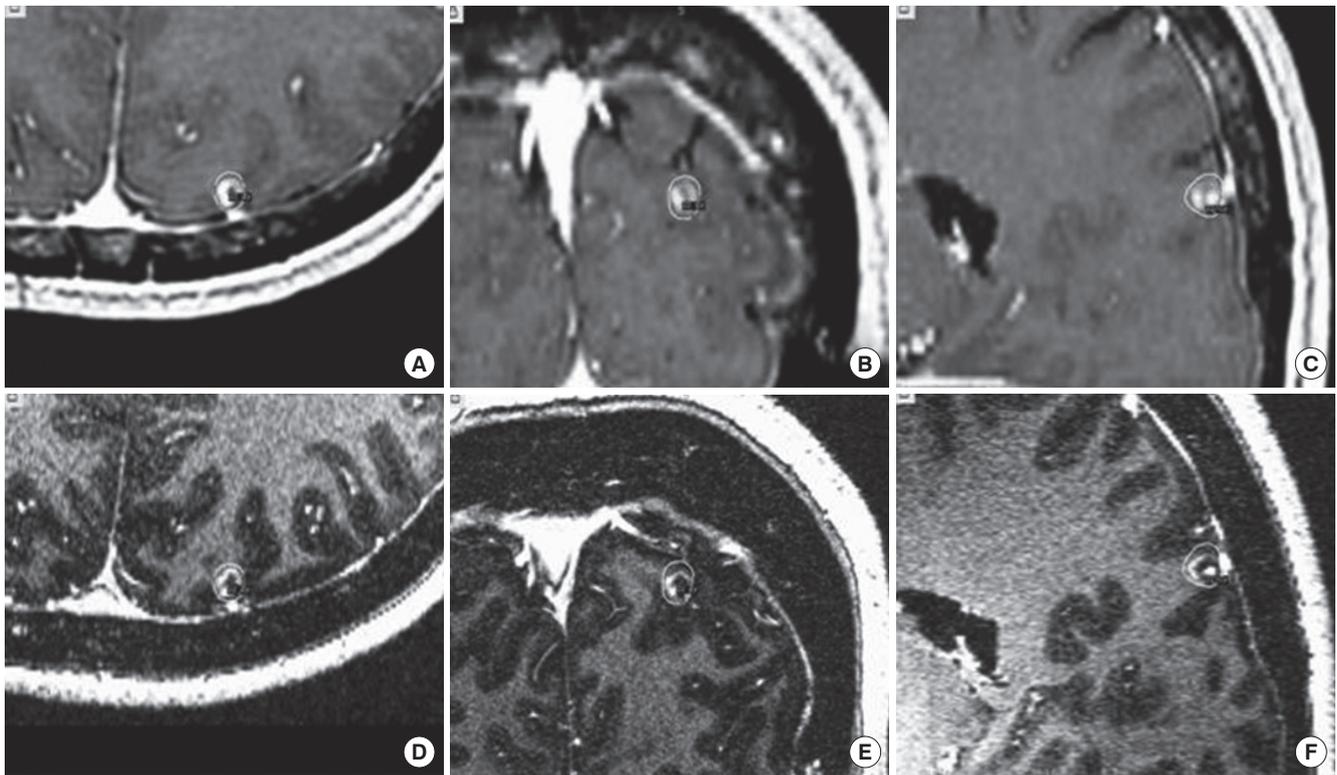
Axial, coronal, and sagittal images of a metastatic lesion in the left parietal lobe in the co-registered images of 1.5 T and 7.0 T magnetic resonance images (MRI). The tumor is demarcated in blue line and its 50%-isodose volume of 22 Gy is marked with yellow line in the left parietal lobe in the axial, coronal, and sagittal view of the co-registered images of 1.5 T (A-C) and 7.0 T MRI (D-F).
